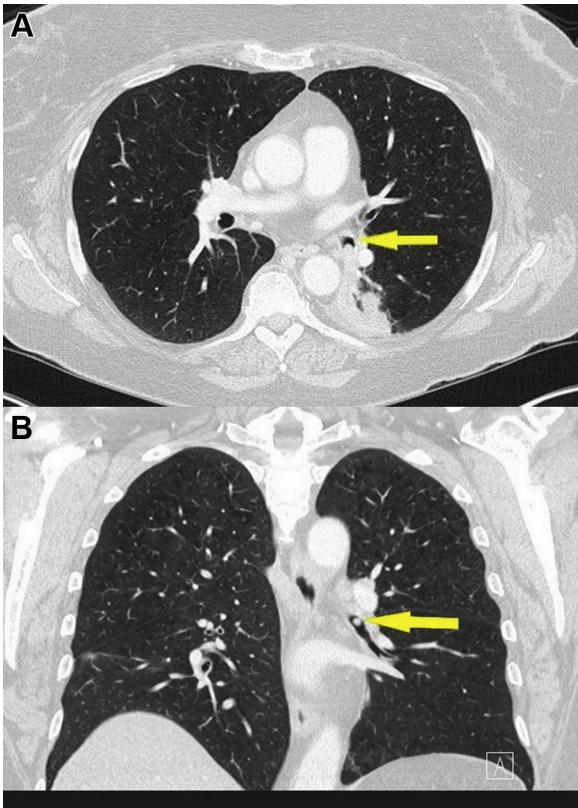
Axial (A) and coronal (B) CT scans of the chest revealing left endobronchial lesion (arrows) in a patient with mild, intermittent hemoptysis. Note left lower lobe atelectasis. A carcinoid tumor was diagnosed at the time of curative therapeutic bronchoscopy.
